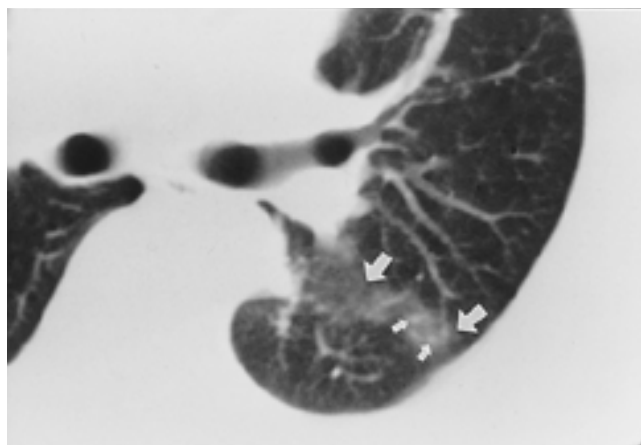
A 57-year-old man with pleural dissemination from adenocarcinoma (not shown) in the peripheral portion of the left lower lobe. CT scan (10-mm collimation) obtained through the carina using a lung window setting shows a poorly marginated band indicating fissural thickening (large arrows). Small nodular thickenings of the pleura (small arrows) are noted along the interlobar fissure. These lesions were not attributed to pleural dissemination at preoperative CT examination. However, surgery revealed pleural dissemination.
